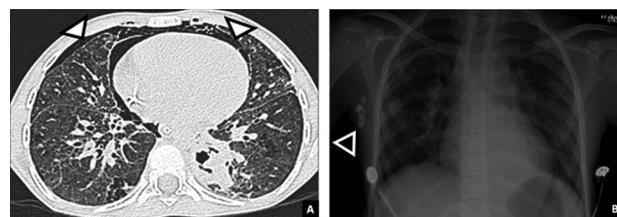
A, Chest CT scan (patient 1) showing bronchiectasis, parenchymal infiltrates, pneumomediastinum (arrowhead), and subcutaneous emphysema (arrowhead). B, Chest x-ray (patient 1) with hilar and parenchymal interstitial infiltrates and multiple calcifications in the right axillary region (arrowhead).
